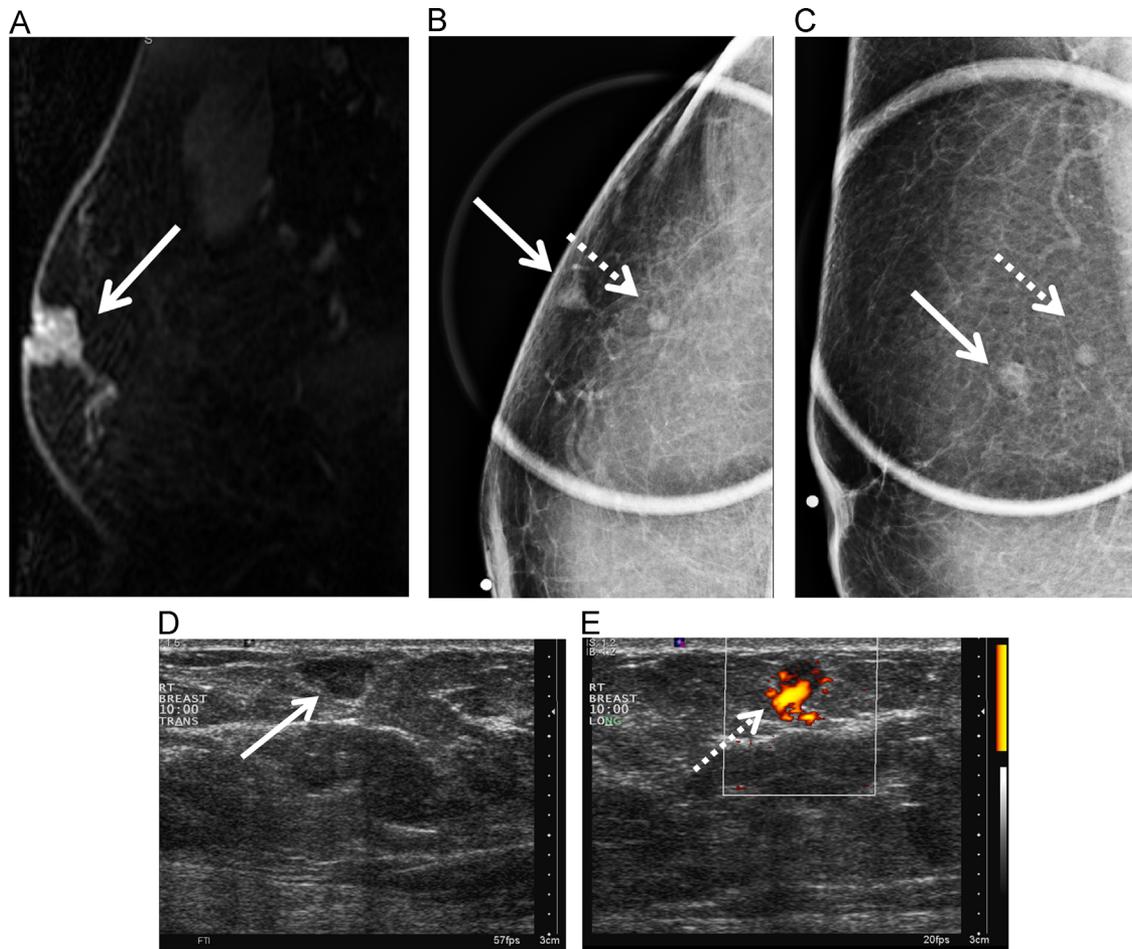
A 71-year-old male with a history of left breast carcinoma, on neoadjuvant chemotherapy. MRI was performed to evaluate treatment response. Sagittal T1-weighted postcontrast fat suppression image of the left breast (A) demonstrates an irregular left subareolar mass (arrows) with associated nipple retraction. Compared to the pretreatment MRI, there was no significant interval change. Subsequently, the patient underwent left mastectomy. The patient returned for a diagnostic mammogram as he had a history of left breast cancer. The patient was 8 years status postleft mastectomy. CC and LM spot compression views of the right breast (B and C) shows a 0.8 cm irregular equal density mass (solid arrow) with indistinct margins in the upper outer quadrant of the right breast at the 10 o'clock position, middle depth. Note that there is also a benign intramammary lymph node posterior to the new mass (dotted arrow). Grey scale US (D) and power Doppler (E) images show a corresponding irregular right breast mass (arrow) at the 10 o'clock position. There is increased vascularity within the mass (dotted arrow). US-guided biopsy showed invasive ductal carcinoma. The patient subsequently underwent right mastectomy. (Color version of the figure available online.)
